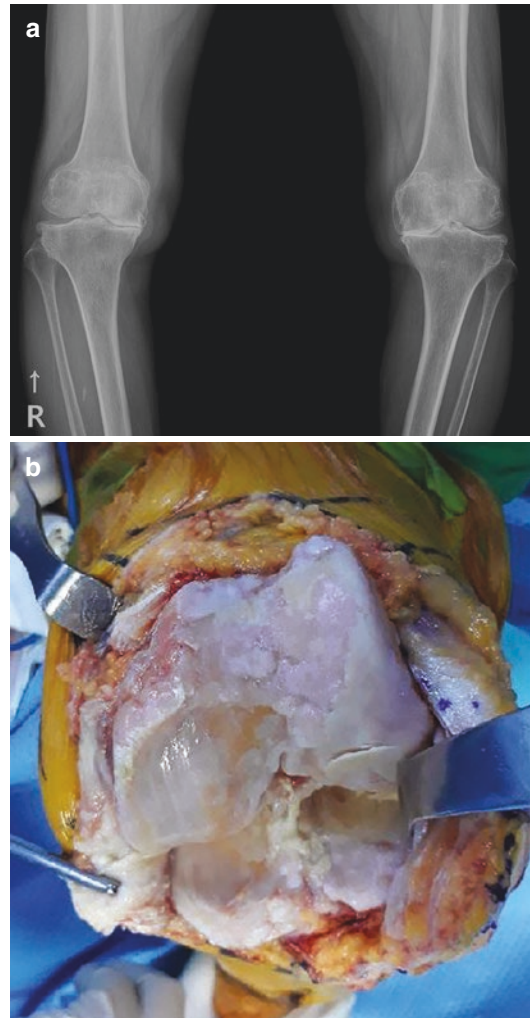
Radiographic and surgical finding of severe OA. (a) KL grade IV OA changes were seen on standing AP radiograph, (b) Severe cartilage wear and osteophytes were found on intraoperative photo
